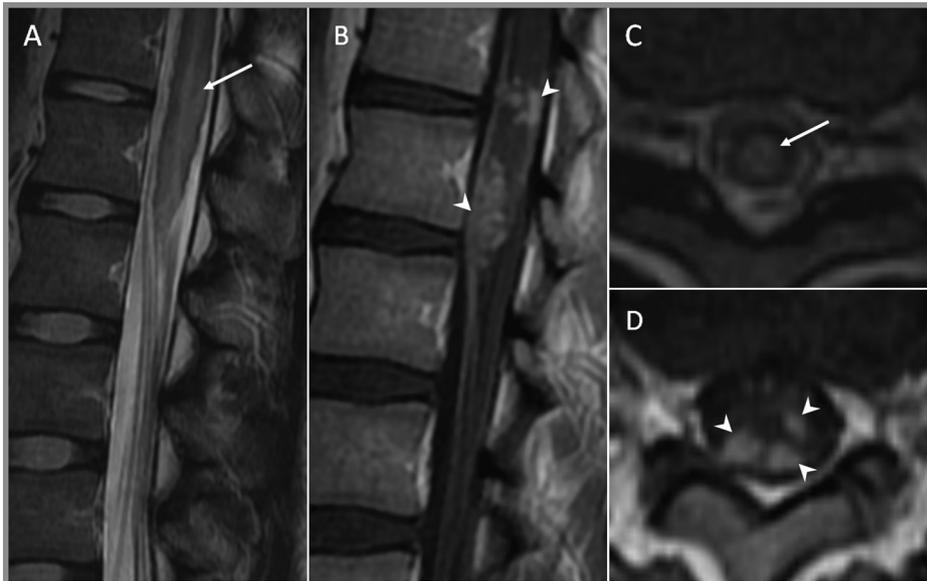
Schistosomal lumbosacral myeloradiculitis. *A, C*, Sagittal and axial T2-weighted and T1-weighted MRI with contrast of the thoracic and lumbar spine demonstrates diffuse intramedullary T2 cord changes (*arrows*). *B*, Contrast studies demonstrate clustering and largely peripheral nodular enhancement of the lower spinal cord including conus (*arrowheads*). *D*, Thick nodular root enhancement within cauda equina is shown (*arrowheads*).
